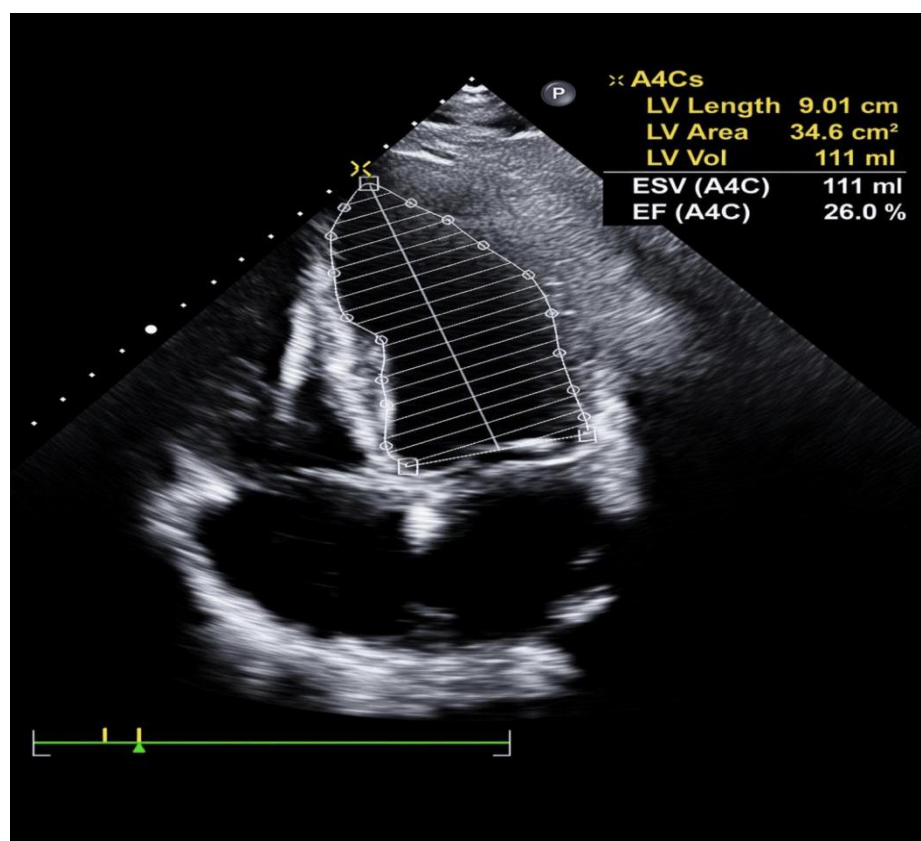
Apical 4-chamber view (end-systole) with LV endocardial tracing.
